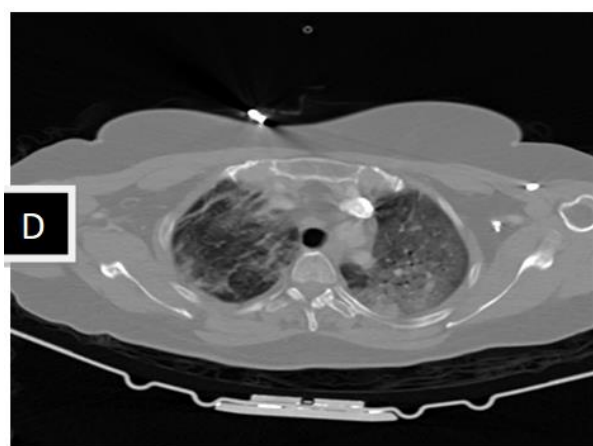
(D). Ground glass images on CT
